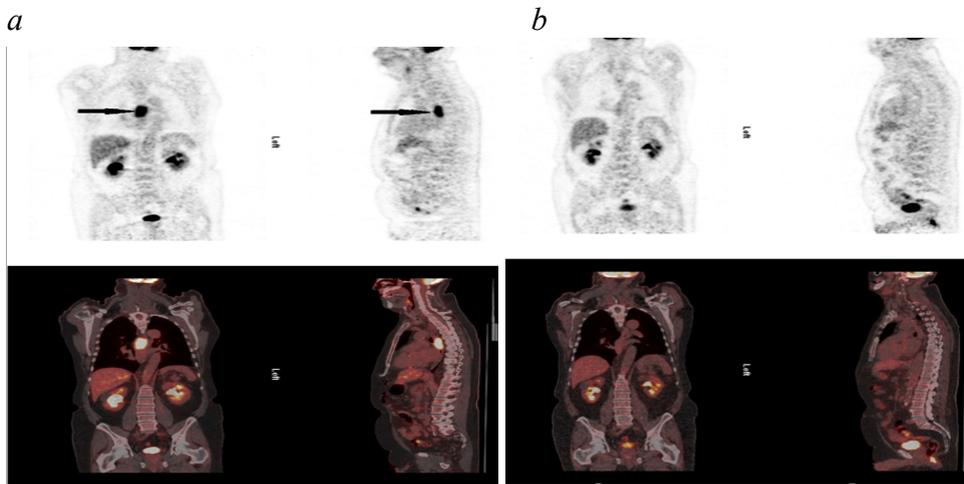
FDG-PET/CT of a 72 years old male patient with T3N0M0 squamos cell carcinoma of middle oesophagus at diagnosis, before neoadjuvant chemo-radiotherapy. Black arrows is site of tumour FDG uptake. Figure. 4b FDG-PET/CT images in unfused and fused states of the same patient as in figure , at follow-up examination four weeks following completion of neoadjuvant chemoradiotherapy. No remaining pathological uptake discovered in the tumour.
